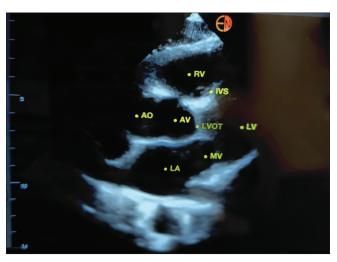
Transthoracic echocardiogram parasternal long-axis image obtained with Kosmos. Al-powered labeling appropriately labels structures- right ventricle, left ventricular outflow track, left ventricle, mitral valve, and left atrium. AO = aorta, AV = aortic valve, IVS = intraventricular septum, LA = left atrium, LV = left ventricle, LVOT = left ventricular outflow track, MV = mitral valve, RV = right ventricle
